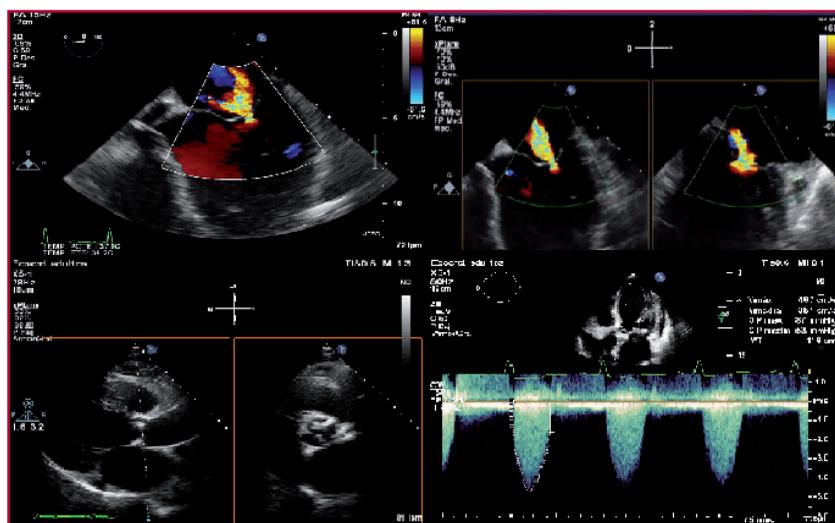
Transthoracic and transesophageal echocardiogram of a patient with severe aortic stenosis and severe mitral regurgitation in the pre-transcatheter aortic valve implantation assessment. The upper images show mitral valve regurgitation severity evaluated through the estimation of the effective regurgitant orifice area (2D transesophageal echocardiography, left image) and biplanar assessment (X-plane type) to estimate the orifice in 3D (right image). The lower images show aortic stenosis assessment through estimation of the outflow tract diameter, the area by planimetry (left) and estimation of the area by the continuity equation using maximum velocity obtained with continuous Doppler.
